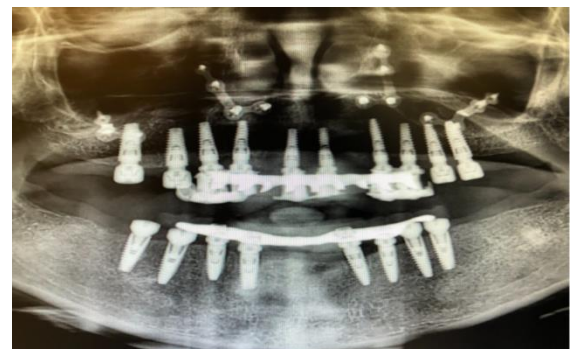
Panoramic X-ray after orthognathic surgery. The provisional upper and lower prostheses have been screwed.
